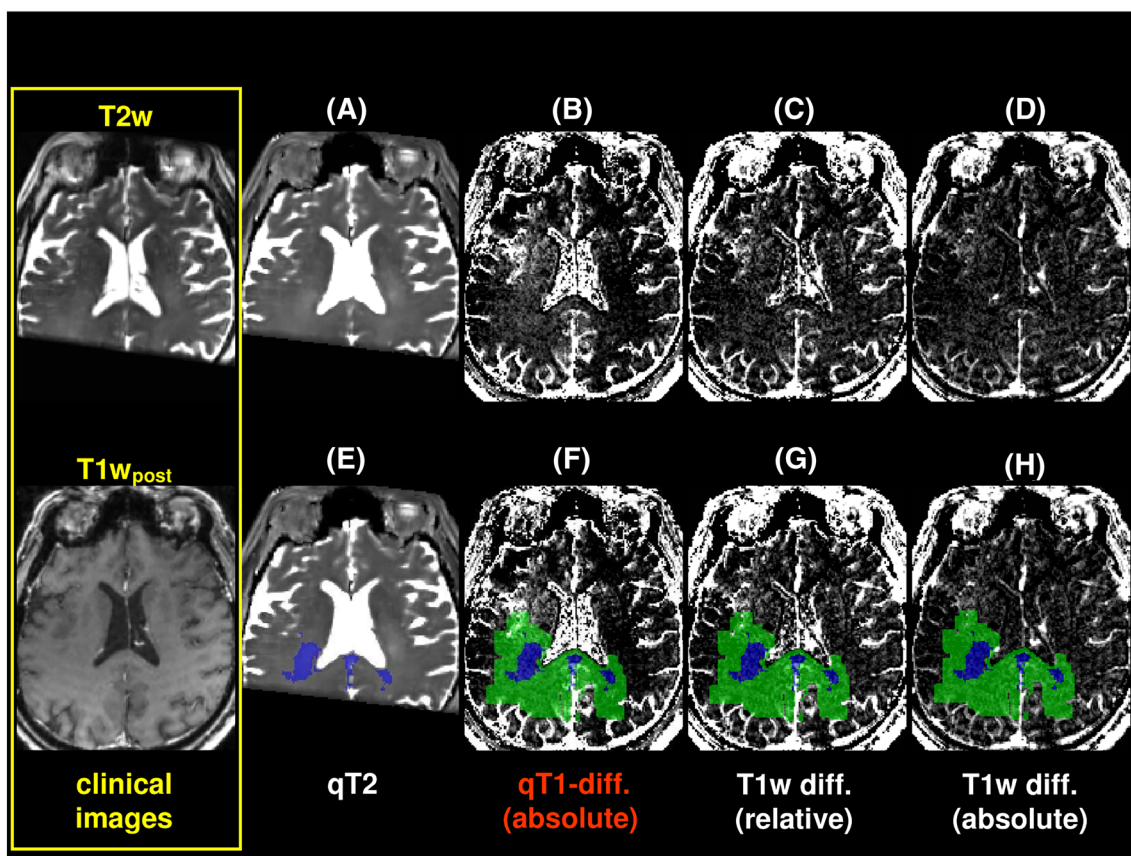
Data of a patient with a left-temporal glioblastoma surrounded by edema; the slice shown depicts the most superior part of the edema region. The yellow frame (left) shows a conventional T2-weighted (T2w) image (top) and the T1w image post contrast agent (T1w_{post}) (bottom) for orientation. Further, the top and bottom rows show from left to right: quantitative T2 (qT2) map (A, E), absolute qT1-difference map (B, F) and relative (C, G) and absolute (D, H) differences of T1w images. In the bottom row, the volume of interest (VOI) masks are superimposed: edema (blue) and 5 mm zone (green). The qT1-difference map (B, F) shows enhancement in the left hemisphere beyond the edema region (blue mask) and 5 mm zone (green mask), which is not visible in the T1w difference images (C, D, G, H)
